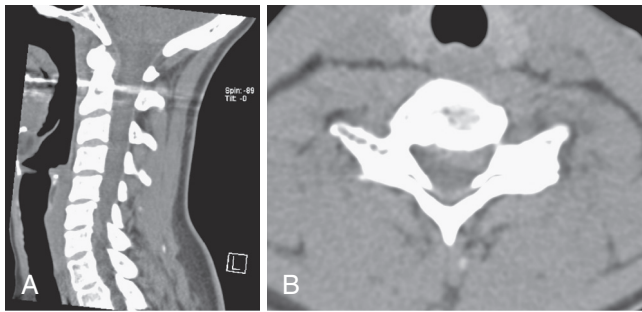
A and B, CT images of C6-7 soft cervical disc herniation.
